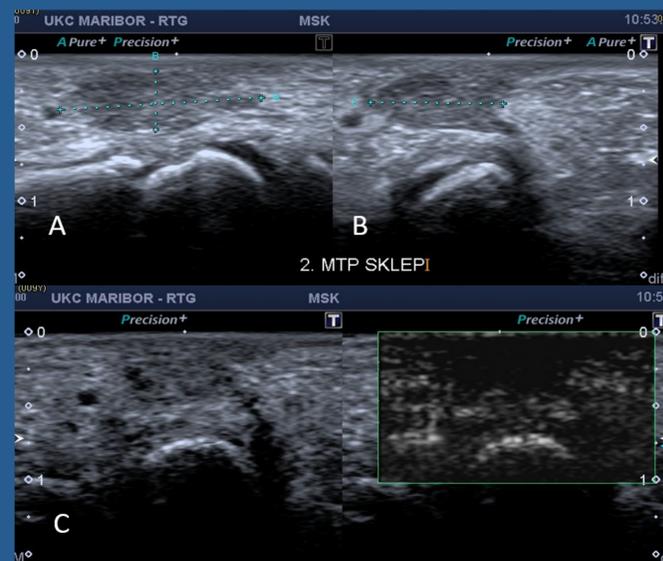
Ultrasound (US) image of the right forefoot demonstrates oval mildly hypochoic heterogenous subcutaneous mass dorsally at the level of second metatarsophalangeal joint in sagittal (A) and transverse (B) plane (between blue markers). Doppler examination (C) does not demonstrate vascularity.
